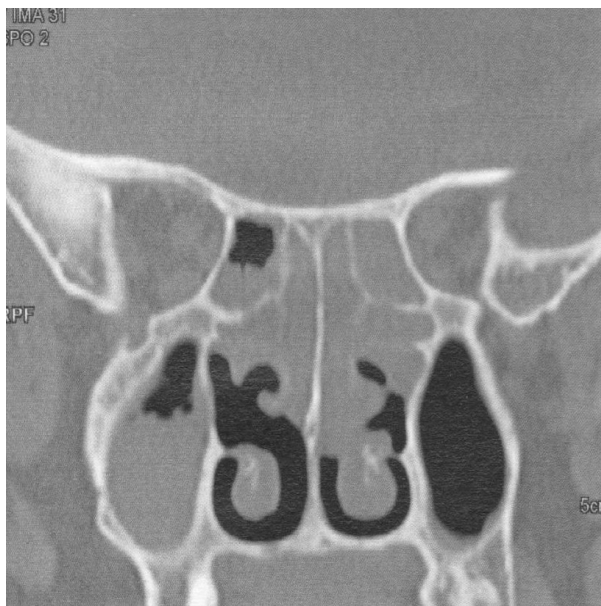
CT image. Native examination
